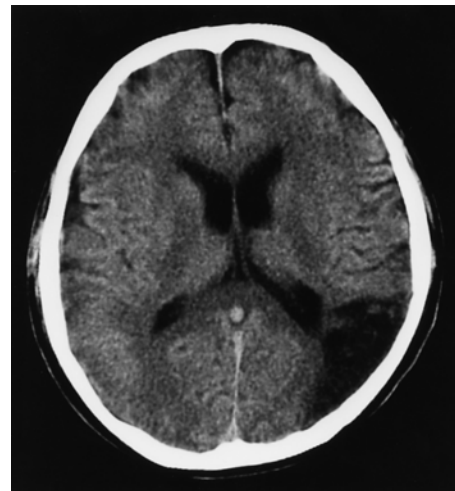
Axial CT scan revealing a low-density area in the left frontoparietal lobe.
